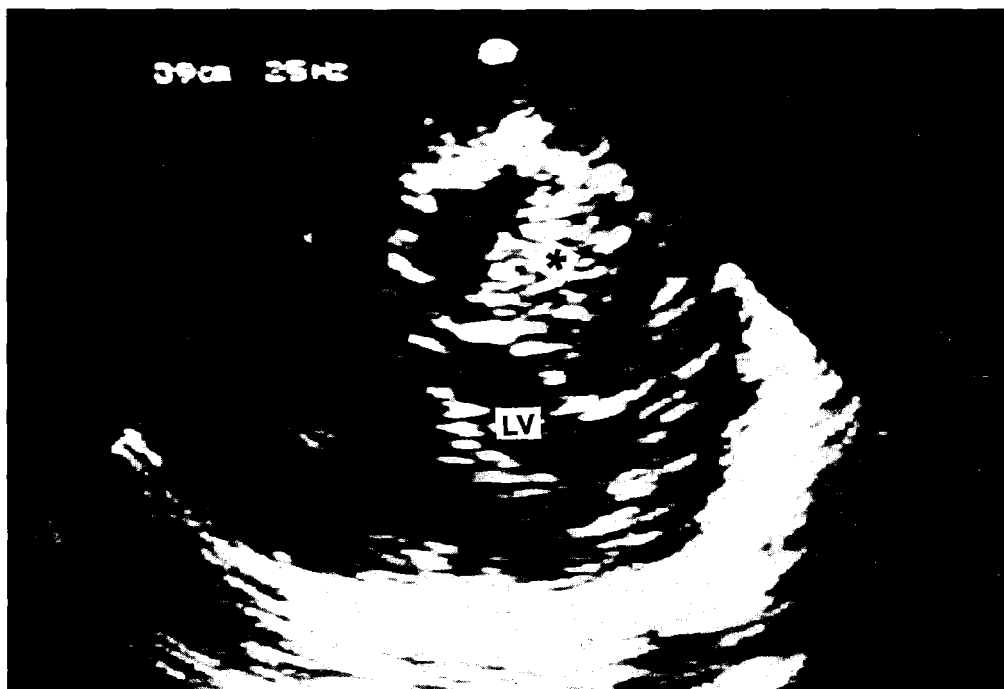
Diagnosis of a parachute mitral valve by a transgastric short axis scan. The morphology of the single papillary muscle (asterix), its insertion and the chordal insertions could be assessed closely by a sequence of scans. Pulsed Doppler studies excluded any inflow obstruction.
